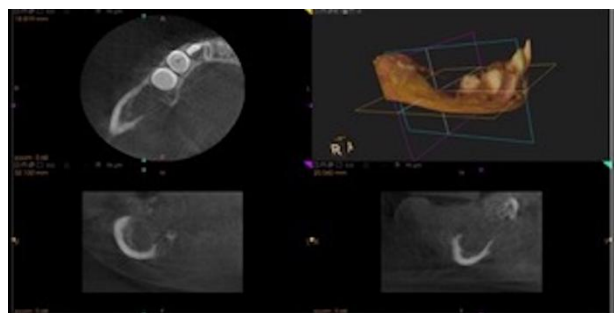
CBCT analysis of the lesion. Lingual plate perforation and extension of the tumor were observed.
